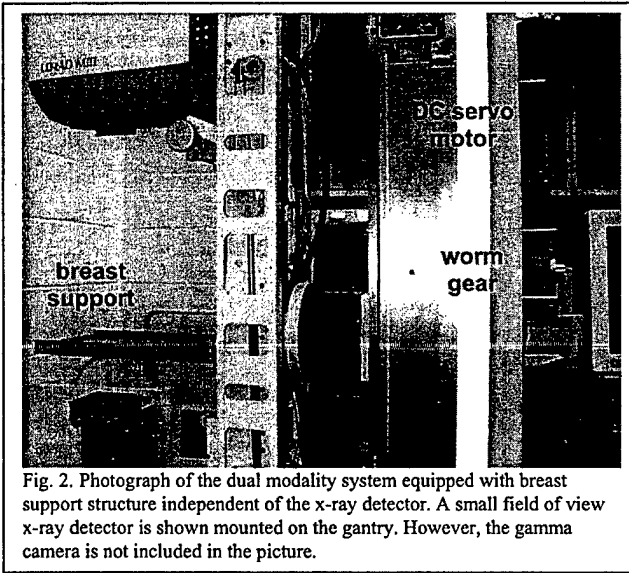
Photograph of the dual modality system equipped with breast support structure independent of the x-ray detector. A small field of view x-ray detector is shown mounted on the gantry. However, the gamma camera is not included in the picture.
